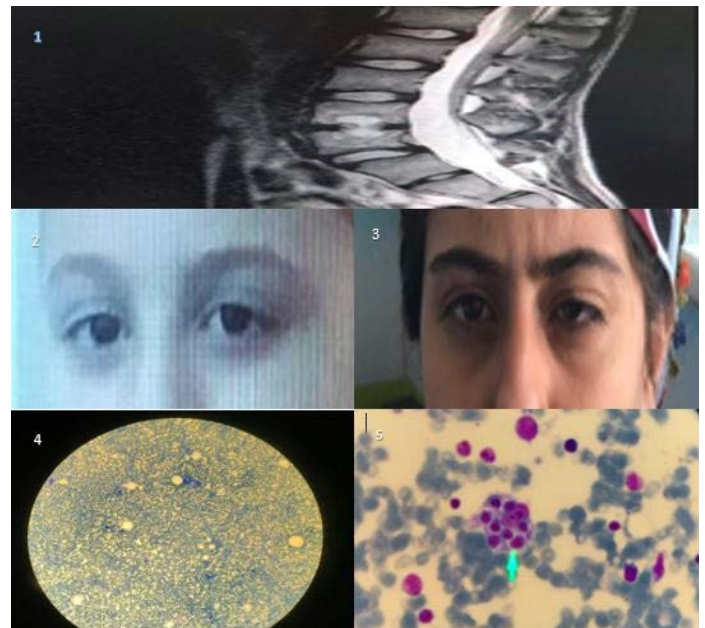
Magnetic resonance imaging of the vertebra in a patient diagnosed with discitis 2A. Image of the eyes of a patient diagnosed with neurobrucellosis. 3A Image of the eyes of a patient diagnosed with neurobrucellosis. 4A. Bone marrow aspiration smear image of a patient diagnosed with IT. 5A. Bone marrow aspiration smear image of a patient diagnosed with HLH
